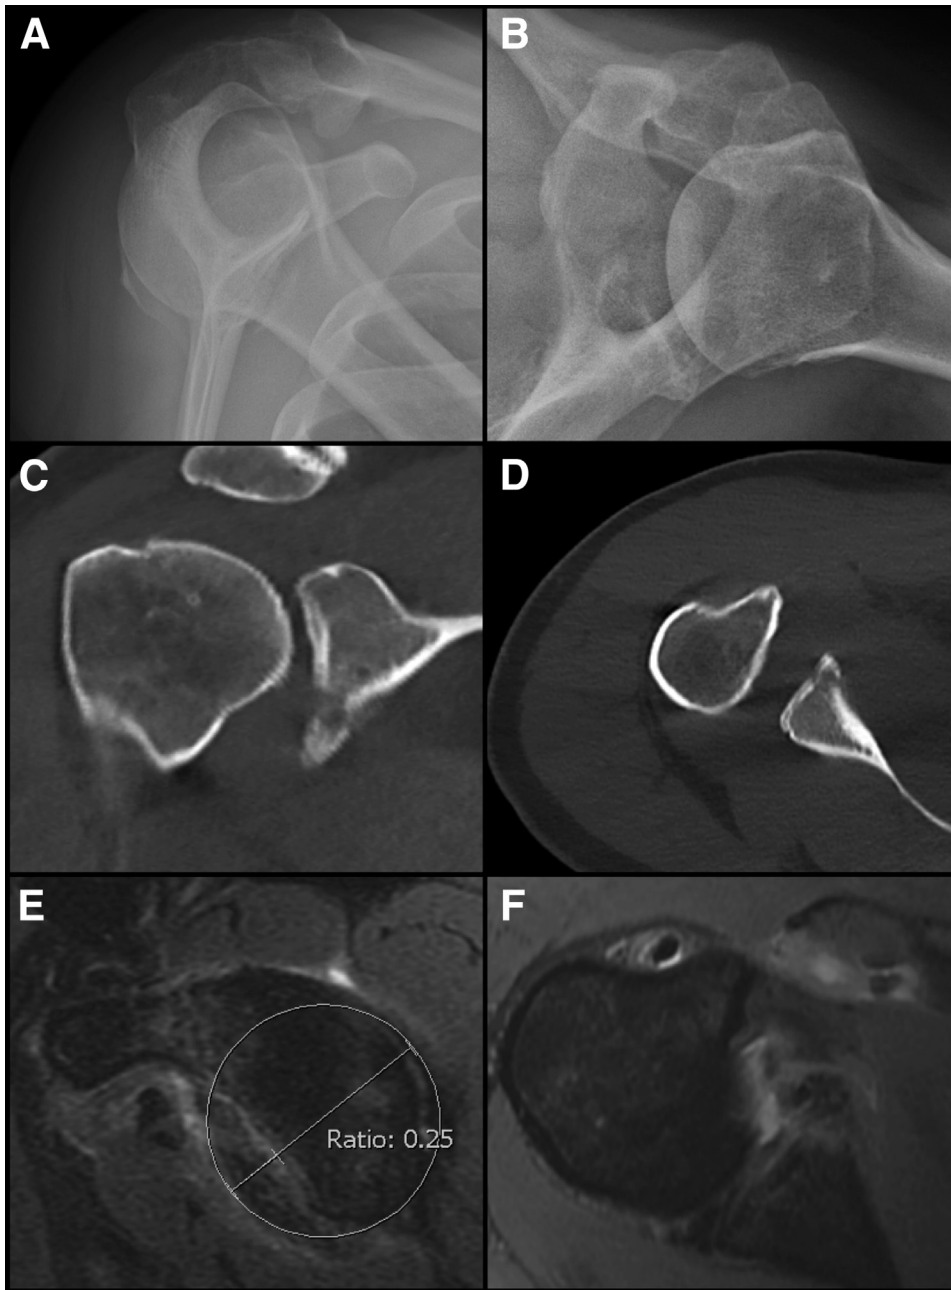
Preoperative imaging of the right shoulder, including plain films scapular Y and axillary views respectively (A and B), computed tomography coronal and axial cross sections respectively (C and D), and magnetic resonance imaging sagittal and axial slices respectively (E and F), which demonstrate a large anterior bony Bankart lesion, which represents 25% of the glenoid width based on the perfect circle method. The perfect circle method is demonstrated in box E, demonstrating the fragment measuring 25% of the total circle diameter.
